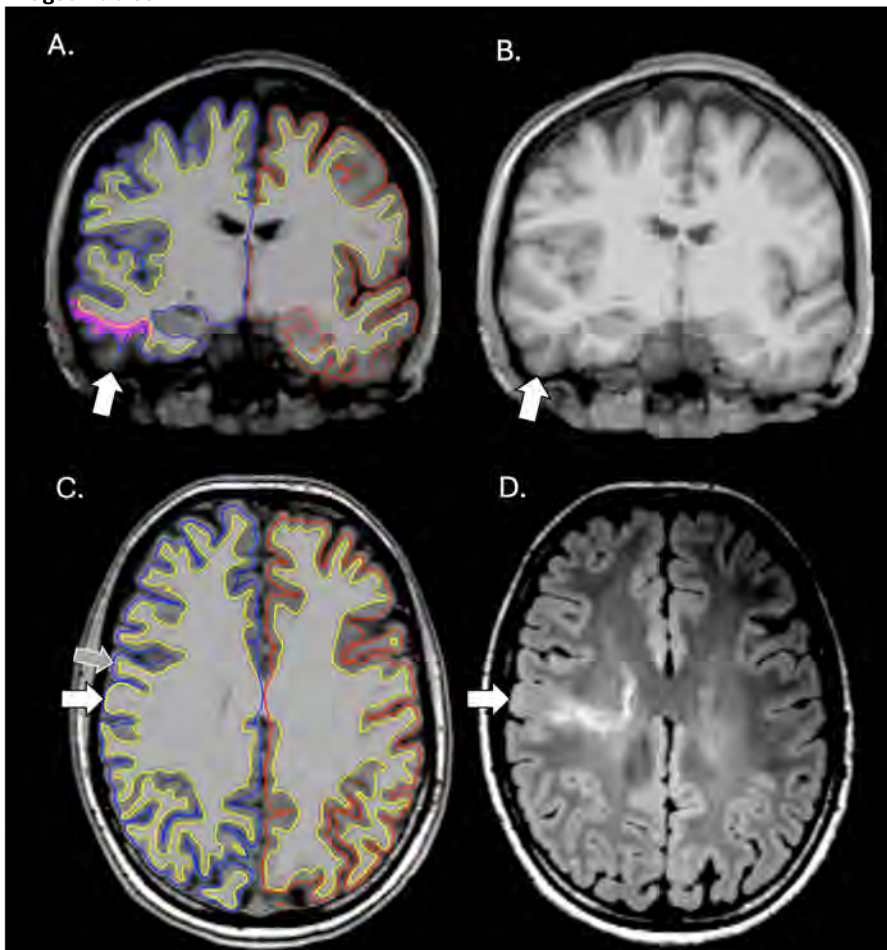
Example of cortical segmentation errors by FreeSurfer. (A) Coronal T1-weighted MR image showing segmented pial (blue, right hemisphere; red, left hemisphere) and white matter (yellow) surfaces generated by FreeSurfer. The white arrow indicates a segmentation failure of the cortical ribbon in the inferior temporal region of the right temporal lobe, resulting in an incorrect prediction of a cluster suspected of focal cortical dysplasia (FCD) by MELD Graph (purple). (B) Corresponding T1-weighted image without segmentation overlays, shown for anatomical reference. (C) The white arrow highlights extension of the predicted white matter surface (yellow) to the outer margin of a dysplastic gyrus. Because the cortex is defined as the region between the white matter (yellow) and pial (blue) surfaces, the dysplastic cortex was excluded from the cortical segmentation, preventing analysis by MELD Graph. The gray arrow indicates an adjacent normal gyrus that was properly segmented. (D) Corresponding FLAIR image showing the dysplastic gyrus (arrow) with blurring of the gray–white matter junction and a subcortical white matter hyperintensity extending toward the ventricular margin, consistent with the transmante sign, classically linked to focal cortical dysplasia type IIb.
